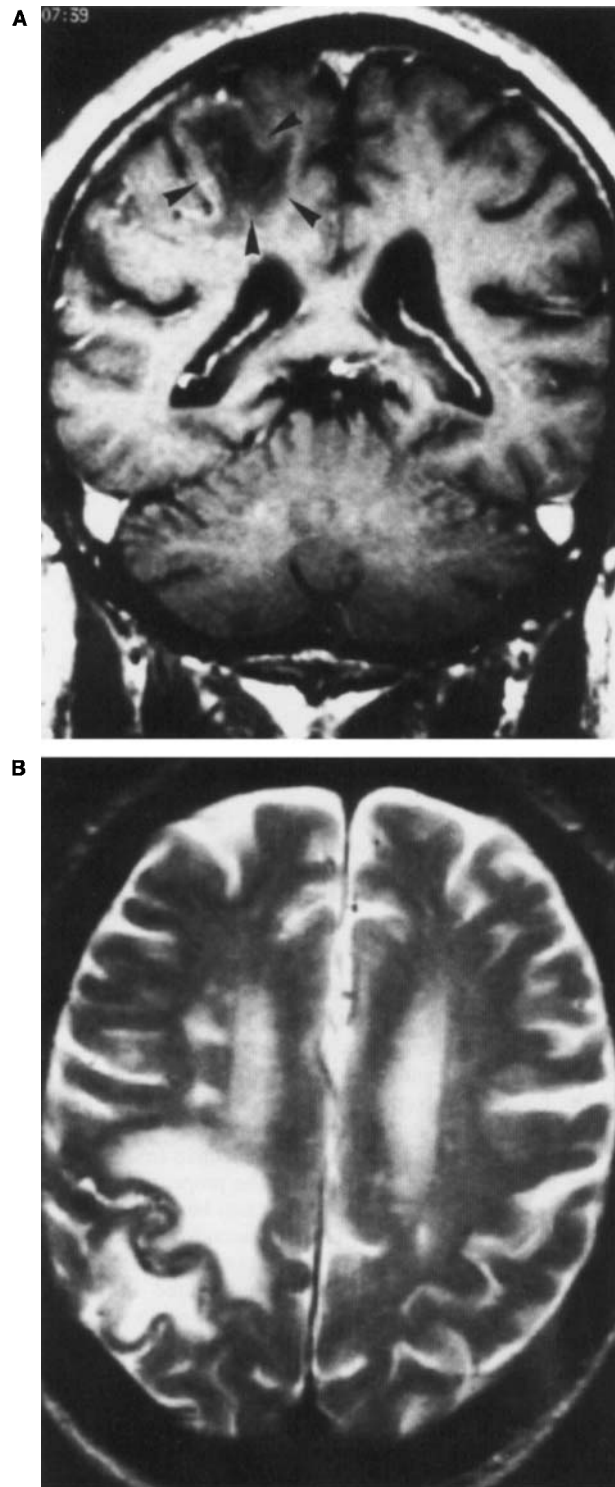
Coronal T1-weighted (A) and axial T2-weighted (B) magnetic resonance images showing the extension of right parietal infarction 3½ months after the onset of symptoms.
